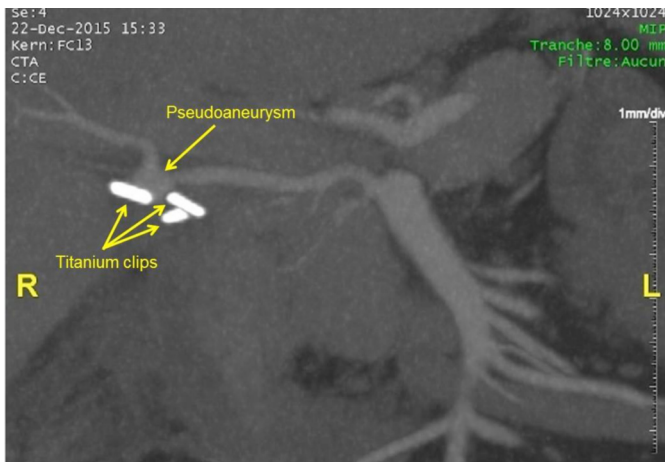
Abdominal CT showing a pseudoaneurysm of the right hepatic artery.
